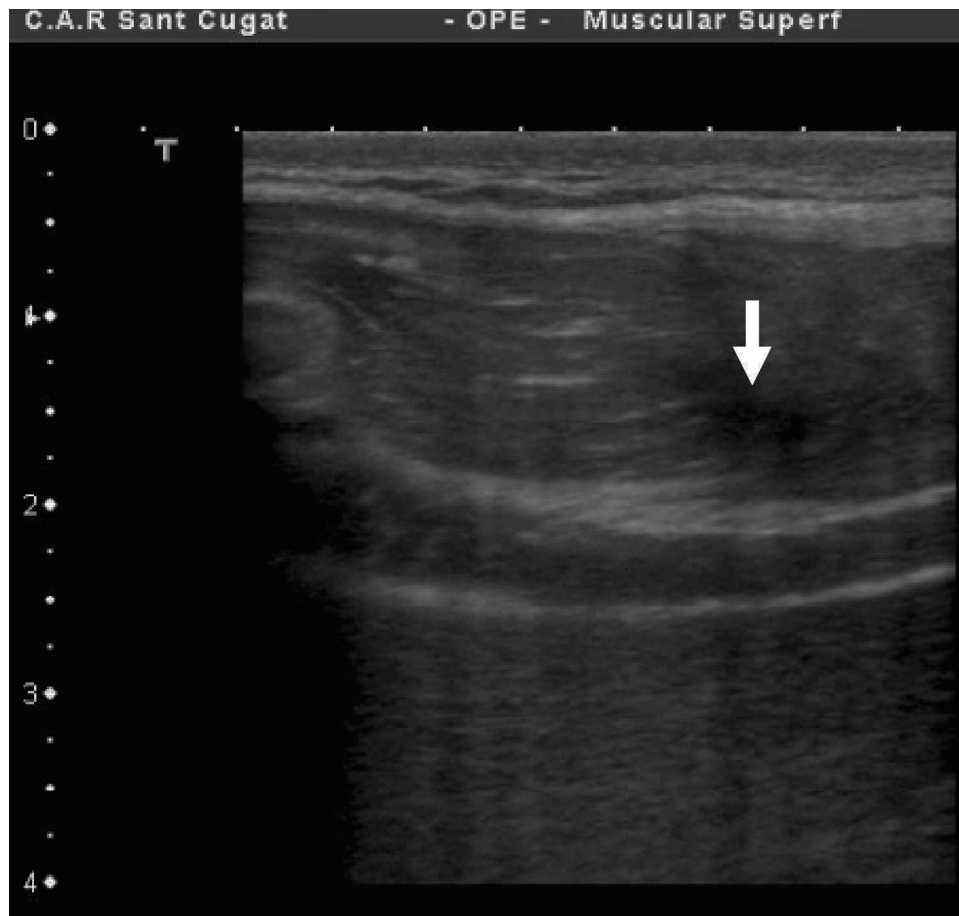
Longitudinal ultrasound image of the same injury.
